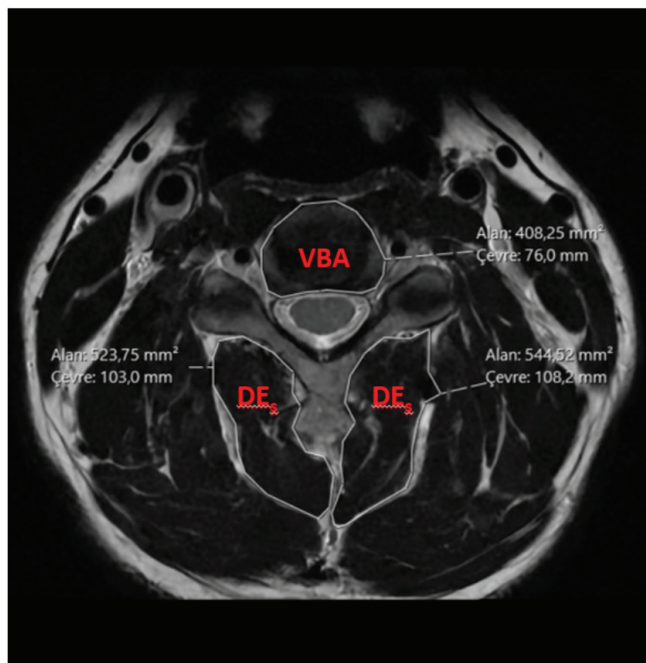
Measurements of the deep extensor muscles areas on axial T2-weighted passing through the C4-C5 disc level
